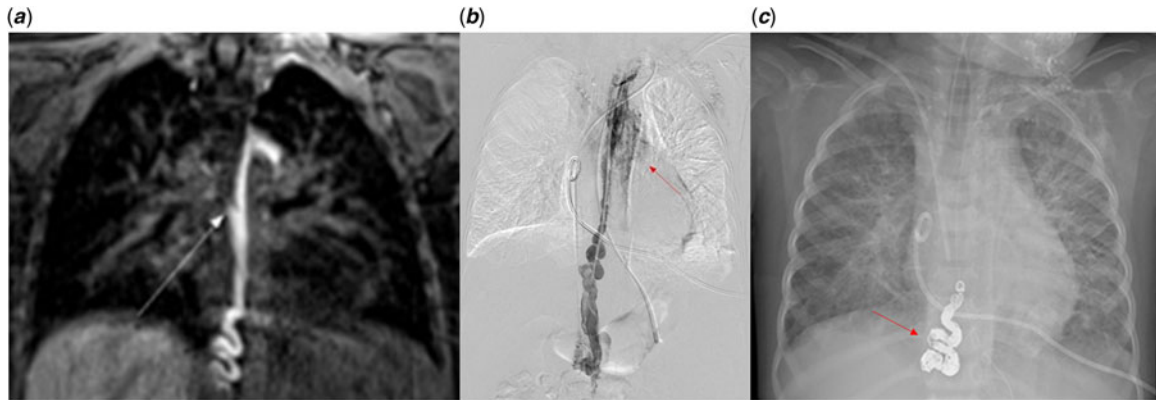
(a) Dynamic T1-weighted magnetic resonance lymphangiography obtained after intranodal injection of gadolinium contrast medium to the inguinal lymph node shows the tortuously dilated thoracic duct connected to the pericardium through an anomalous mediastinal lymphatic vessel (arrow). (b) Direct catheter lymphangiography with the tip in the central conducting duct at the abdomen confirmed a reflux from the thoracic duct into dysplastic lymphatic channels in the mediastinum and left pericardial space (arrow). Note the pigtail catheter in the pericardial space. (c) Chest radiograph obtained after thoracic duct embolisation shows multiple microcoils (arrow) and glue cast at the lower thoracic spine level.
